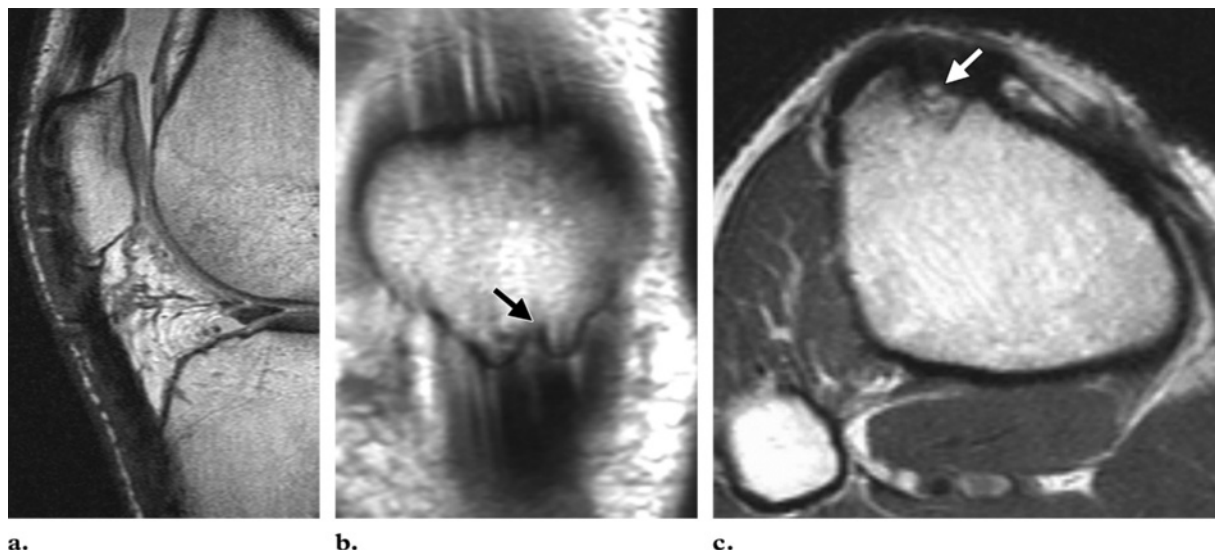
Bone–patellar tendon–bone graft. (a) Sagittal proton-density–weighted fast spin-echo MR image shows signal heterogeneity of the patellar tendon at the graft harvesting site. (b) Coronal T1-weighted MR image shows a patellar cleft (arrow). (c) Axial proton-density–weighted fast spin-echo MR image at the level of the anterior tibial tuberosity shows a bone defect (arrow) from bone plug harvesting.
